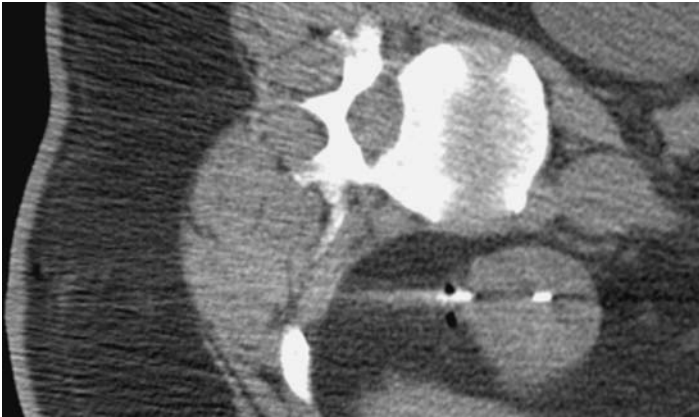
Percutaneous biopsy in a 41-year-old woman with Von Hippel–Lindau syndrome. CT confirms positioning of the 18-gauge cutting needle in a solid renal mass.
